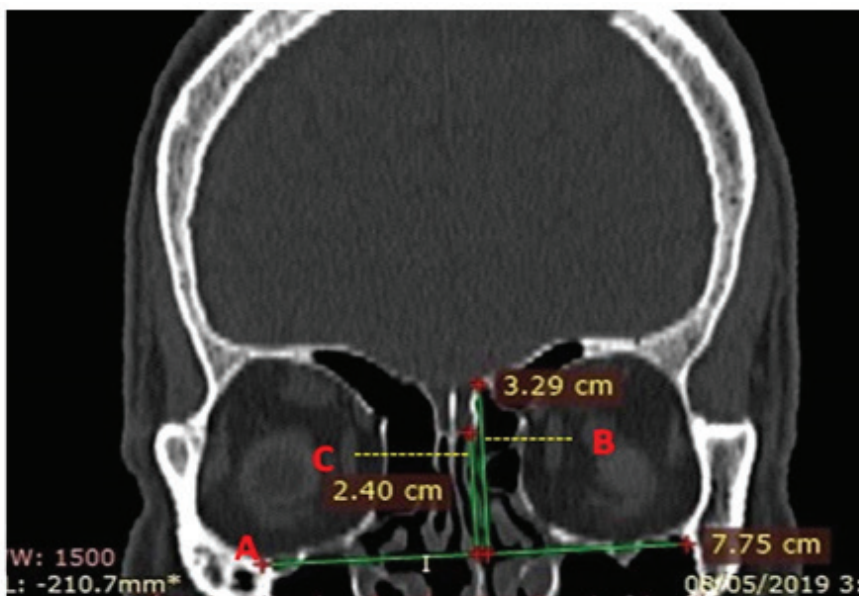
Showing coronal section of Multidetector computed tomographic scan of the patient at the level of infraorbital foramen.
